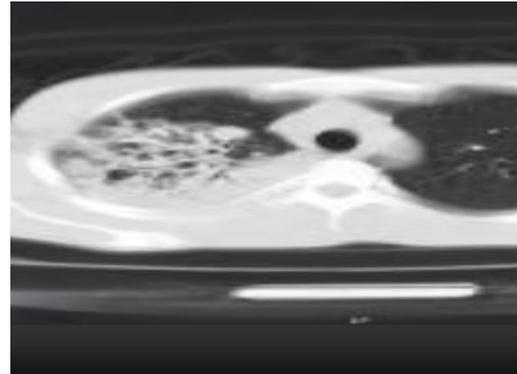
Showing HRCT of same patient showing consolidation with air bronchogram in right upper lobe segments.
